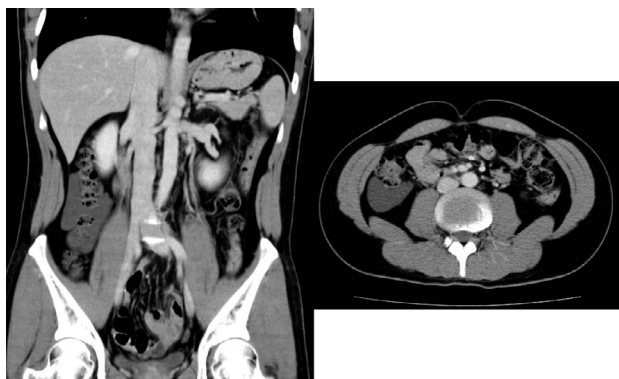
Contrast-enhanced computed tomography showed a 7.2-cm-diameter smooth-surfaced, well-demarcated mass behind the right colon.
